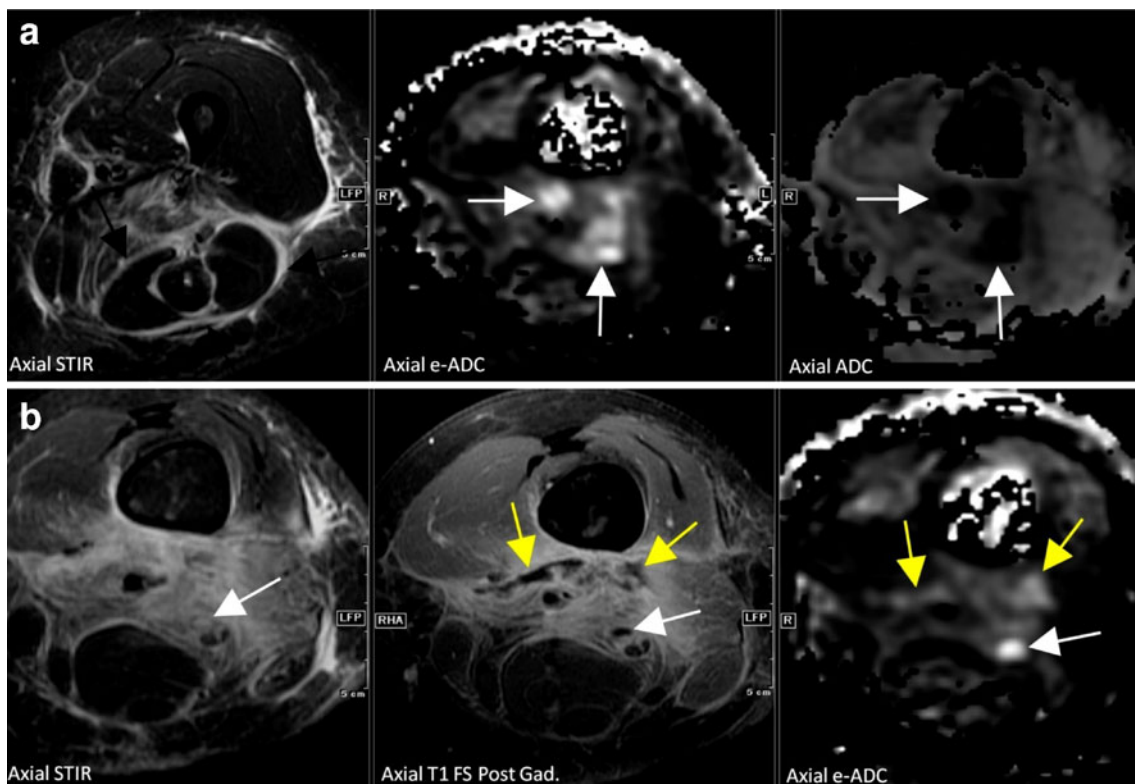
a (case 2): Axial STIR MR image demonstrates extensive hyperintensity of the fasciae (*black arrows*). There is intermuscular edema without a discrete fluid collection. There are e-ADC hyperintense (*white arrows*) and ADC hypointense (*white arrows*) intermuscular foci in keeping with restricted diffusion. b (case 2): Axial STIR image shows intermuscular edema and a small fluid collection (*white arrow*) near the sciatic nerve. Post-gadolinium image shows fascial enhancement and small ill-defined foci of hypointensity with mild
